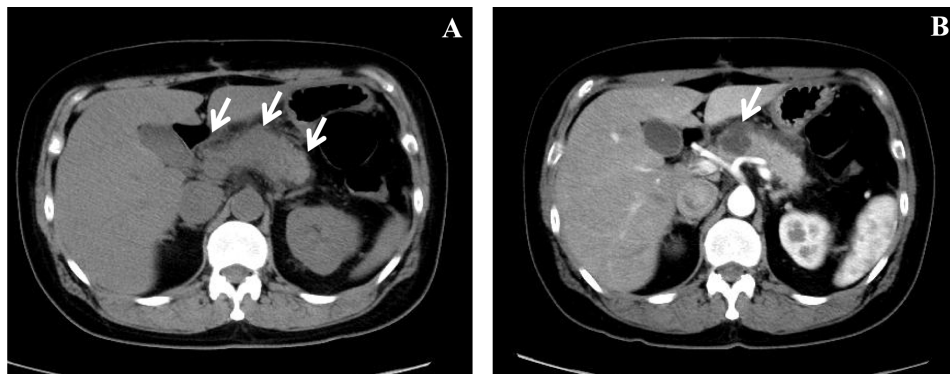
(A) Transverse computed tomography (CT) scan reveals a large, edematous pancreas, and peripancreatic inflammatory changes (white arrows). (B) Transverse CT scan reveals a pseudocyst in pancreas (white arrow).
